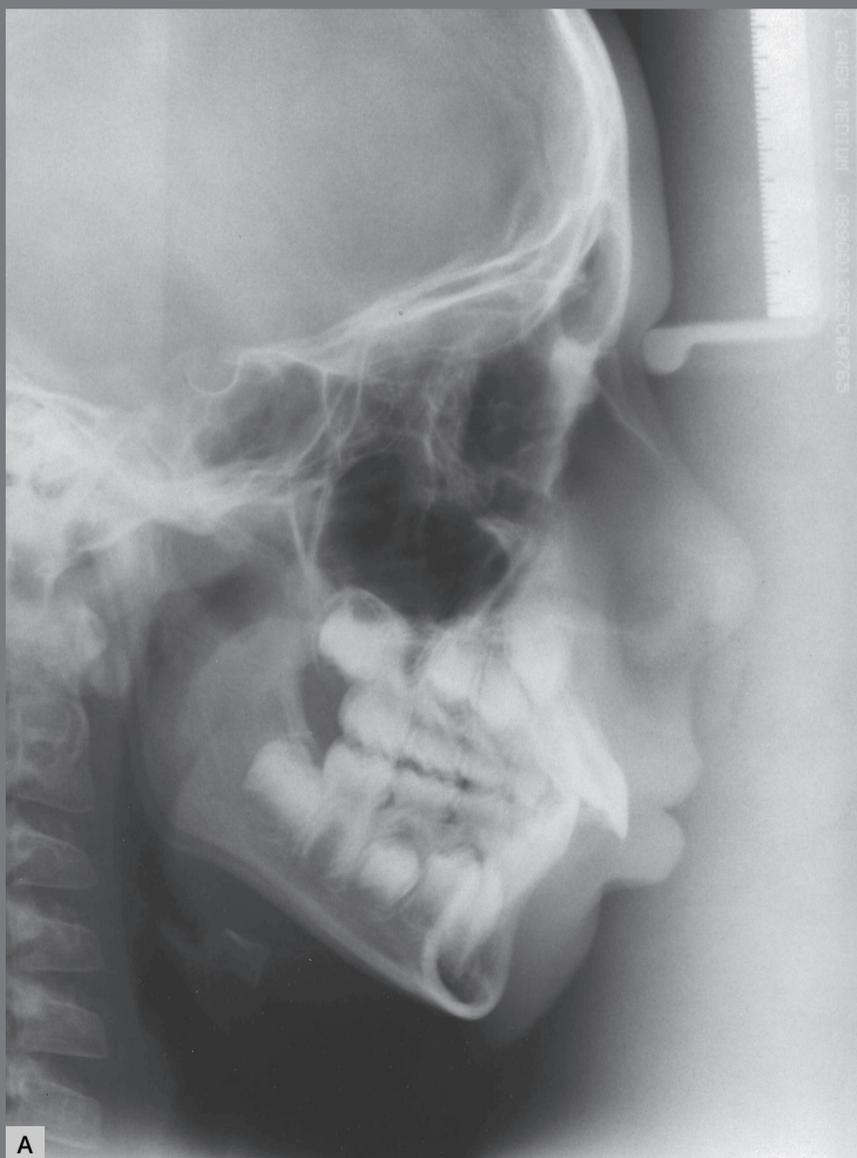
Initial cephalometric radiograph of facial profile (A) and cephalometric tracing (B).
